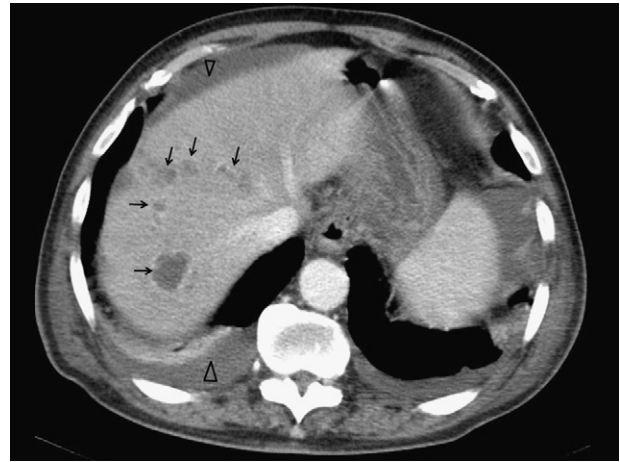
Transverse CT scan in portal phase showing well-circumscribed hypodense cavities with peripheral rim enhancement in the right hepatic lobe (arrows). Note peritoneal and bilateral pleural effusion (arrowheads).
